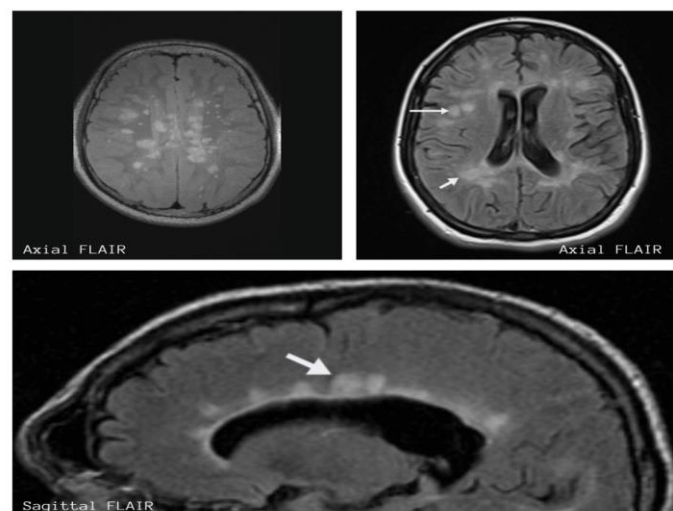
Axial and Sagittal FLAIR sequence images of a patient with Dawson fingers configuration and juxtacortical hyperintense lesions.
